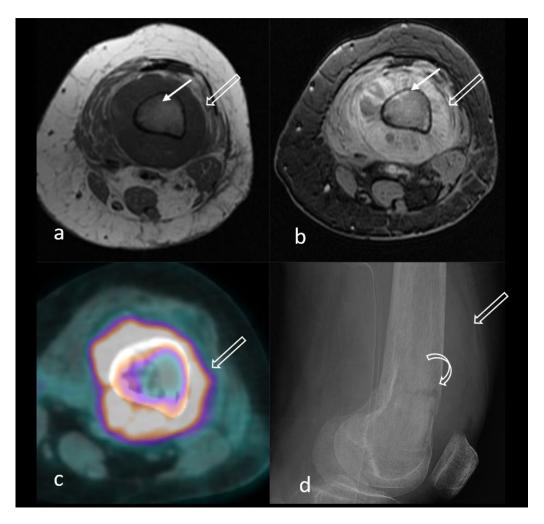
Representative images of Axial T1, Axial fat-saturated postcontrast, PET-CT scan, and Lateral radiograph of the distal left femur. (A) Axial T1, (B) Axial fat-saturated postcontrast, (C) PET-CT scan, (D) Lateral radiograph of the distal left femur. There is a T1 hypointense signal and enhancement of the distal left femur (arrow on panels A and B) with extraosseous soft tissue component (open arrow on panels A-D), which demonstrates avid contrast enhancement and F-18 fluorodeoxyglucose uptake. Mildly displaced transverse pathologic fracture of the distal femur (curved arrow on panel D).
